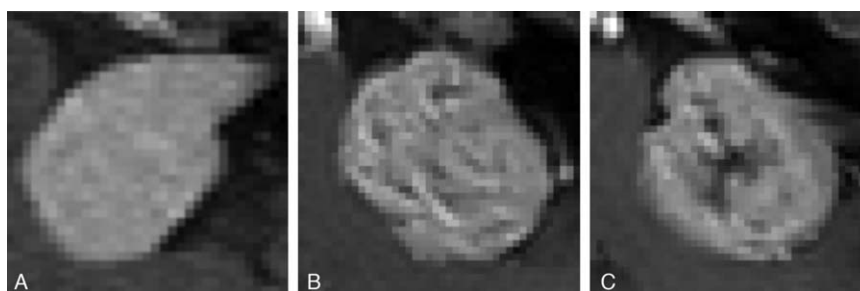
Examples of different vestibular schwannoma tumor textures on contrast-enhanced MRI scans. The depicted tumors have comparable volumes. Part A: near-homogeneously enhanced lesion. Part B: small irregularities in texture. Part C: Heterogeneously enhanced lesion with an apparent hypo-intense area. MRI indicates magnetic resonance imaging.
